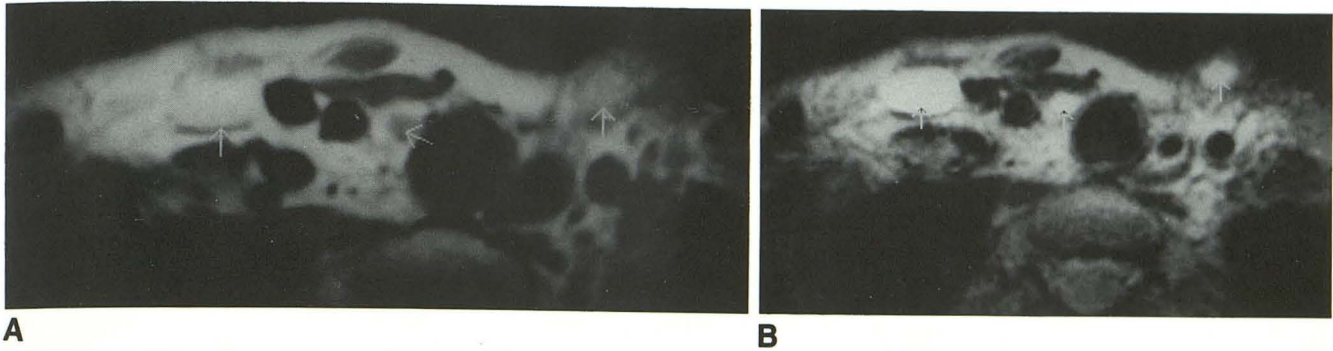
Spin-echo 400/15 (A) and 2250/80 (B) MR images with surface coil. Recurrent papillary adenocarcinomas (arrows) in the cervicothoracic junction showed medium or high intensity on T1-weighted images (A) and high intensity on T2-weighted images (B). The fine-needle aspiration biopsy was done before the MR study in this patient. High intensity on T1-weighted image may be explained by bleeding caused by the fine-needle aspiration biopsy. Abnormal accumulation in these tumors was not observed on ^{201}Tl scintigraphy (C).
